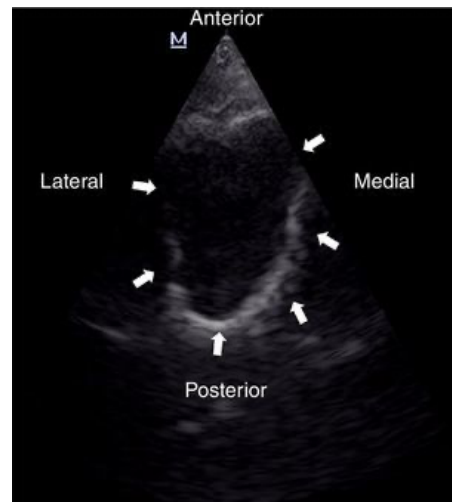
(i) Right maxillary sinus ultrasound using a phased-array probe demonstrating well-defined hyperechoic walls of the sinus (arrows), consistent with a “complete sinusogram.” (ii) Comparative ultrasound of bilateral maxillary sinuses showing (a) right side with a complete sinusogram and (b) left side
